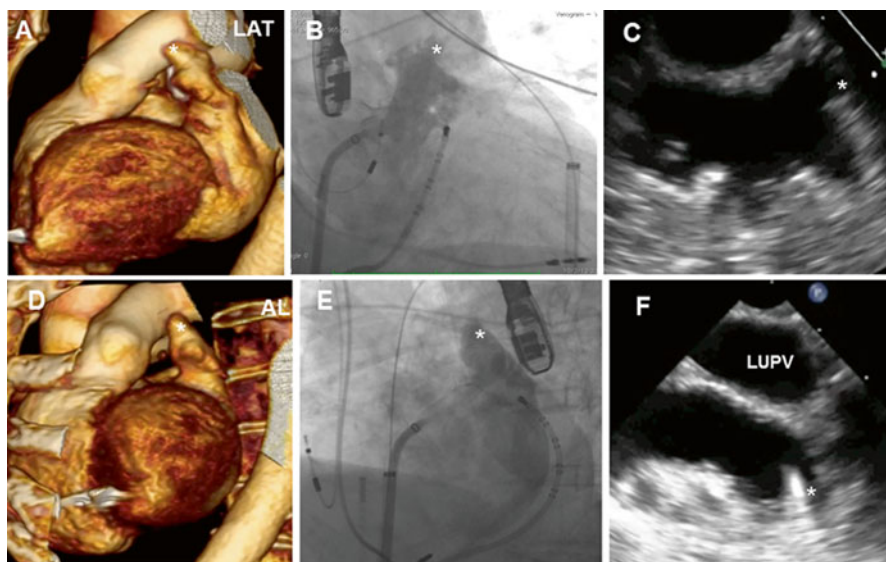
Imaging. The lateral view of the CT (panel a), RAO caudal fluoroscopic view (panel b) and the 120–135° TEE view (panel c) are complimentary views that can provide information regarding LAA size and morphology. The most anterior aspect of the LAA can be seen in the lateral view of the CT that is analogous to a true left lateral view. The anterior lateral view of the CT (panel d) is analogous to a shallow, 30° LAO fluoroscopic view (panel e). Panel (f) demonstrates a 60° TEE view with the magnet tip in the anterior lobe. The *white asterisk* represents the anterior aspect of the LAA. *LAT* lateral, *AL* anterior-lateral, *LUPV* left upper pulmonary vein (Reproduced from Koneru et al. [14] with permission)
